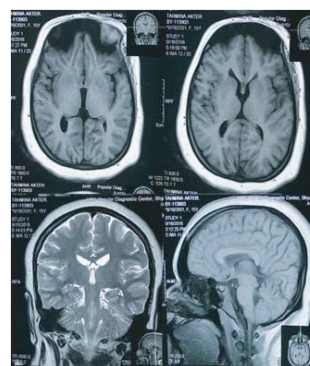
MRI of brain showing normal midline brain structures
